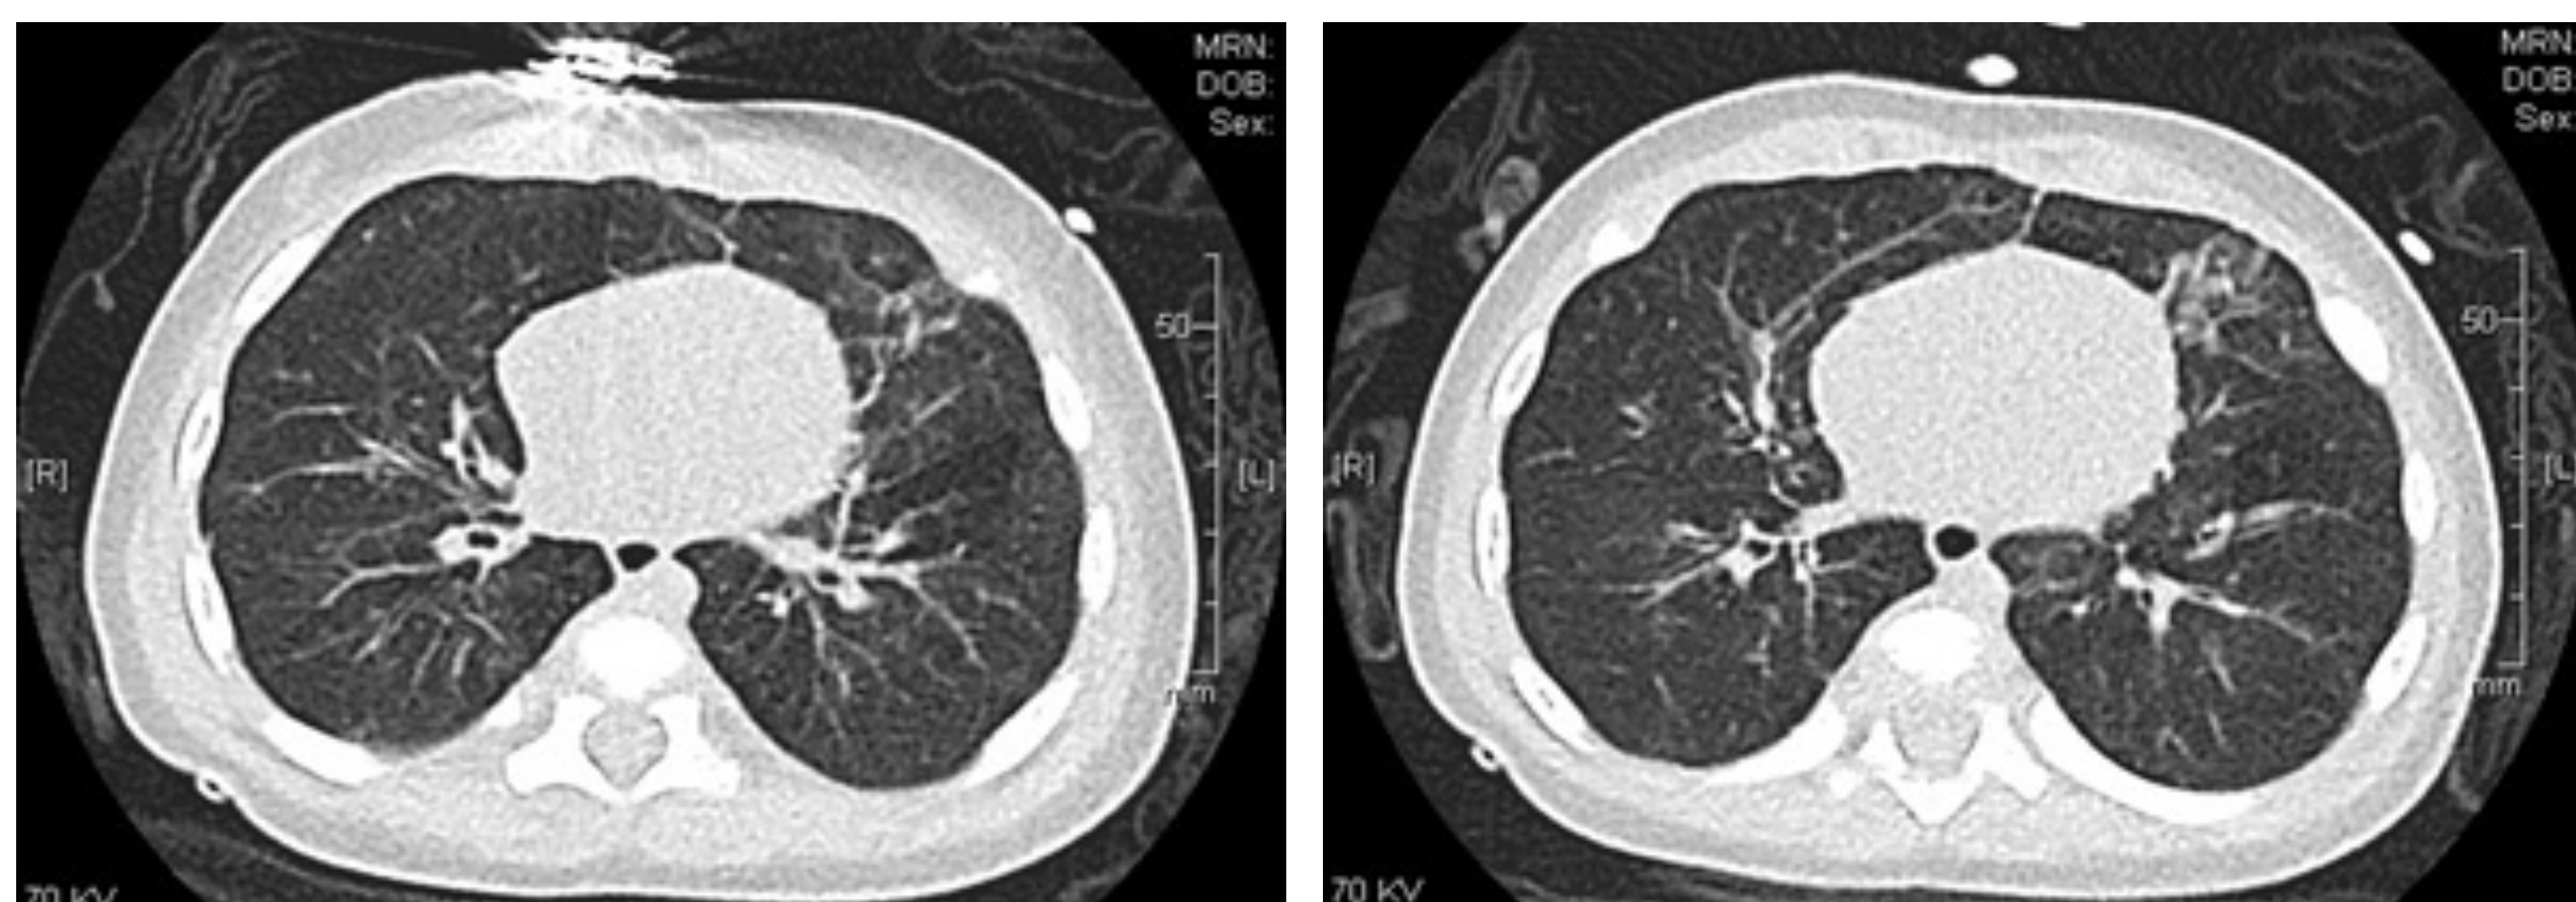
Chest CT showing bronchial wall thickening most severe in the upper lobes, subtle heterogeneous attenuation of the lungs likely secondary to air trapping, and areas of bandlike, patchy, and nodular ground glass opacities.
